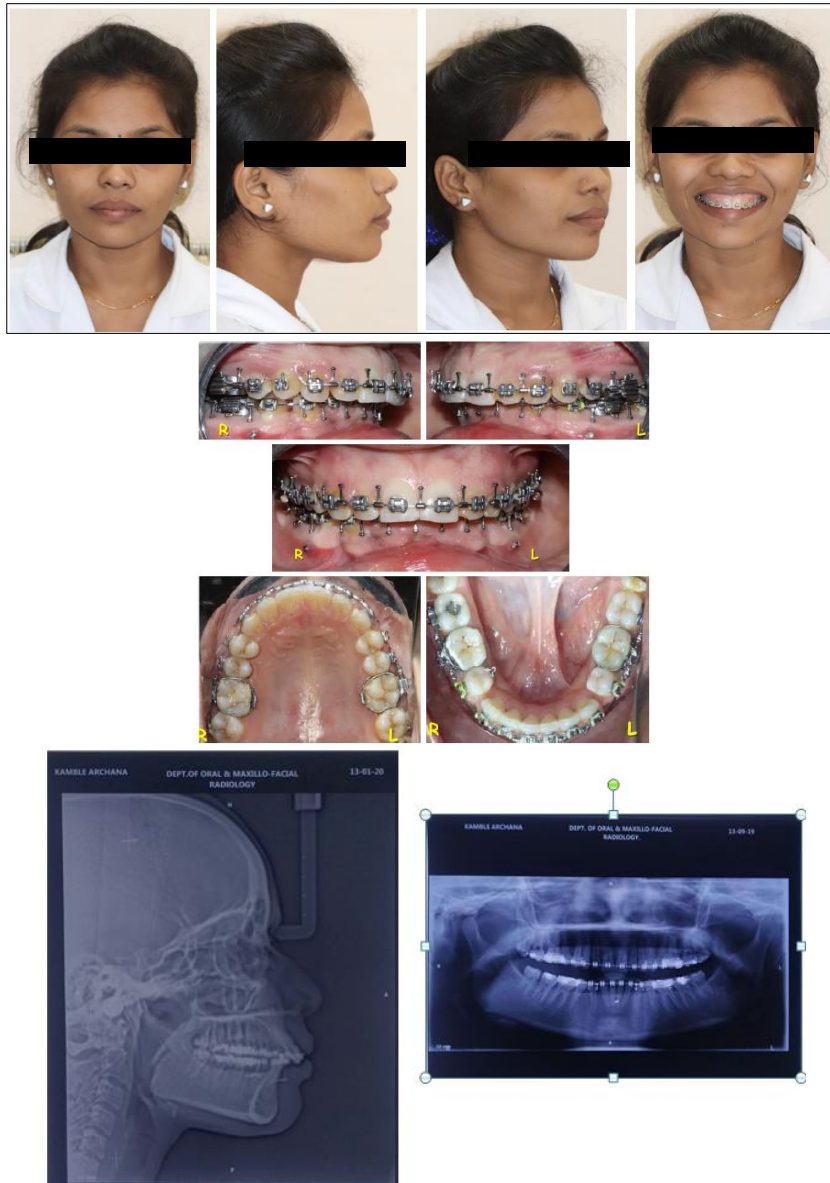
Pre surgical extra oral photos, intra oral photos and radiographs
